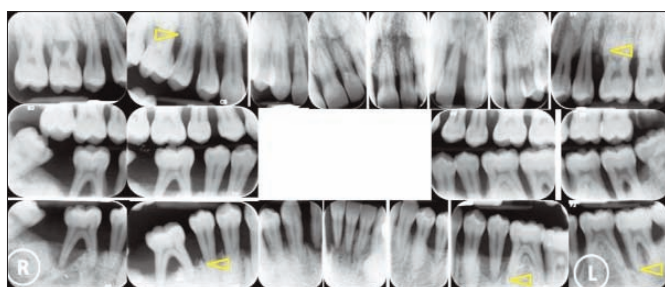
Intra-oral periapical and bitewing radiographs taken at one year follow-up showing an aggressive and generalized horizontal alveolar bone loss of 7 to 8 (yellow arrows) millimetres in both arches.
